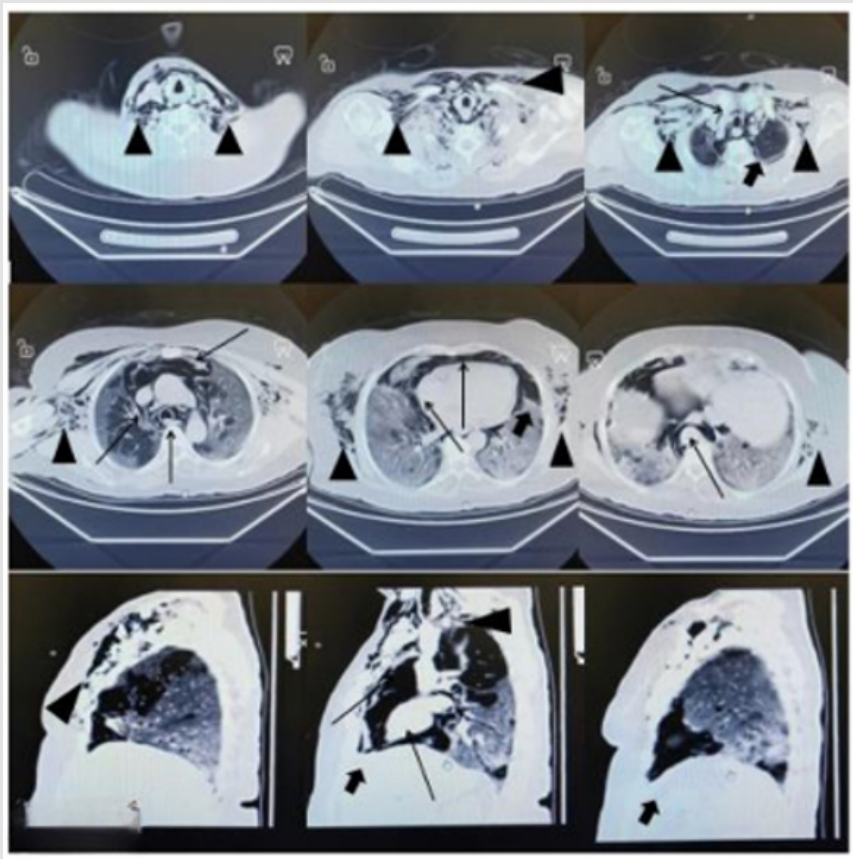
Axial and sagittal Chest CT scans of a patient 8 days after admission showing ground glass opacities in both lungs. Subcutaneous emphysema starting from the neck, continuing to anterior and lateral walls of the chest and extending to both axillary regions. (black triangle), pneumomediastinum in the pericardial area and surrounding all mediastinal structures (long arrow), as well as a pneumothorax on the left side (short arrow).
